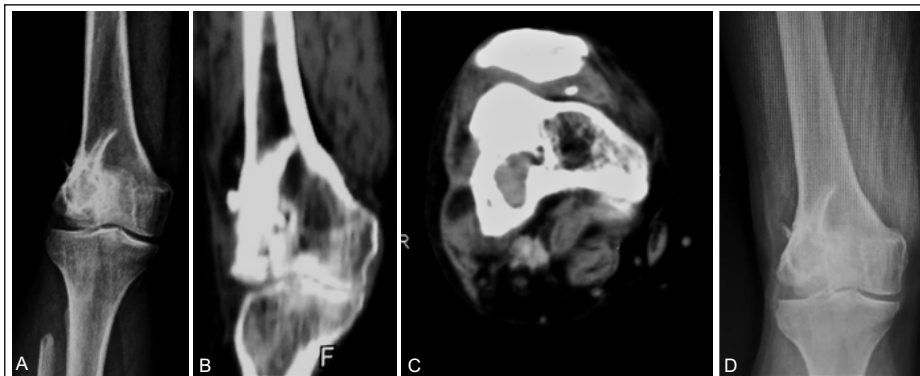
A 59-year-old male who underwent extended curettage and reconstruction with reverse fibular graft in 2012 for giant cell tumor (GCT) of lateral femoral condyle, presented with a computed tomography (CT) report of GCT recurrence in 2014 (CT done from another hospital) (a-c). Since clinical features were not suggestive of a recurrent lesion, we decided to observe. Even 5 years of observation, the lesion is radiologically stable and the patient is asymptomatic (d).
